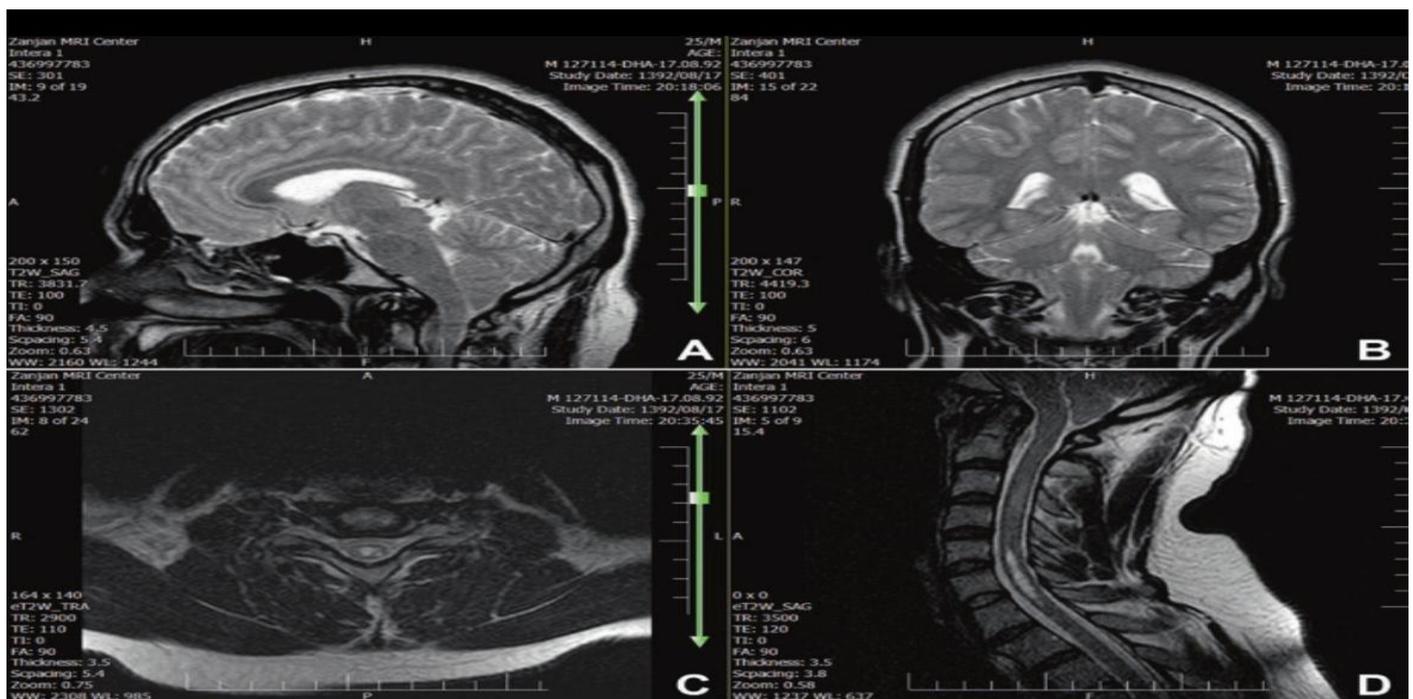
Magnetic Resonance Image (MRI) Showing Syrinx at the Cervical Spinal Cord at C6-C7 Level.
